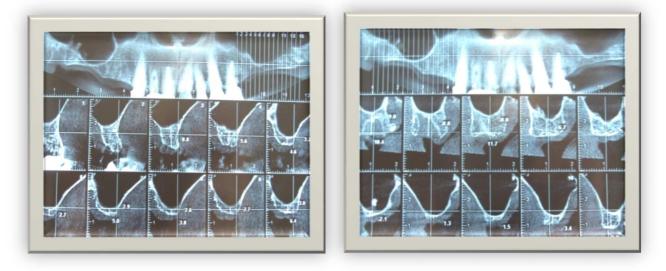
Pre-surgical radiographs for one of the patients (male, 46). Not enough bones, both sinus cavities almost equal
